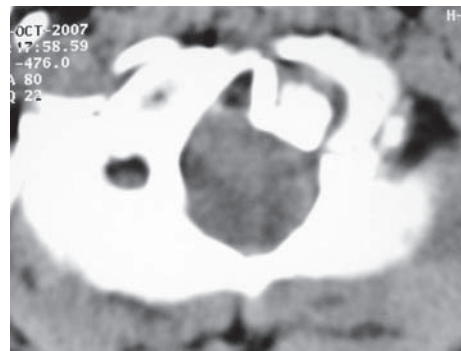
Axial cuts of non contrast CT of craniovertebral Junction showing retro-pulsed fractured segment without compression of cervical spinal cord.
